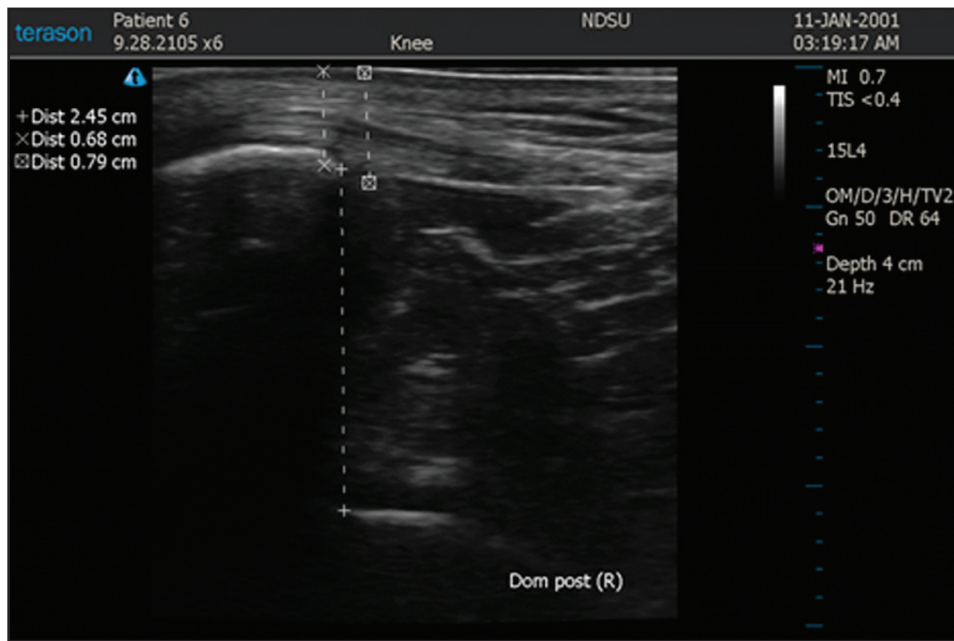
Images from Terason t3200 diagnostic ultrasound.
